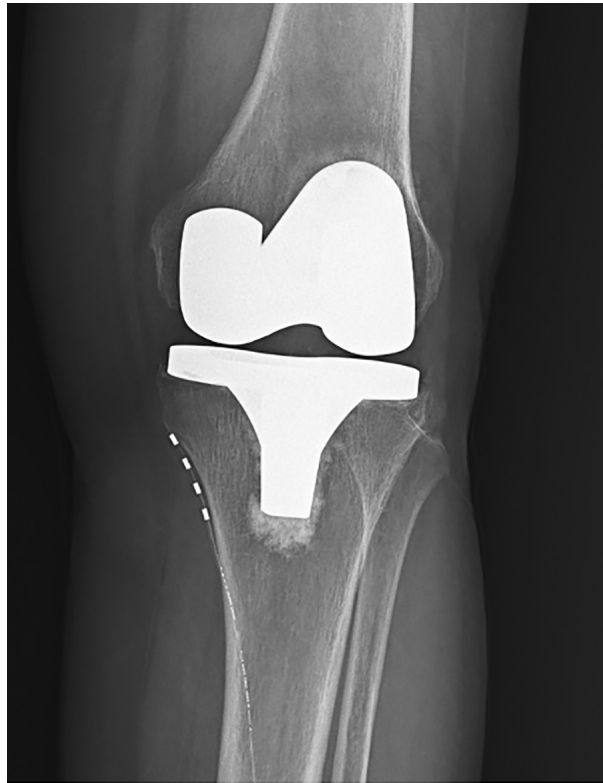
X-ray of device positioning at the IPS nerve. IPS: infrapatellar saphenous.
